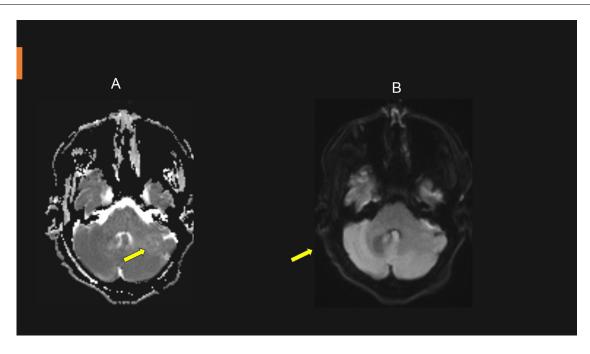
(A) and (B) Axial DWI and ADC map showing no diffusion restriction.
